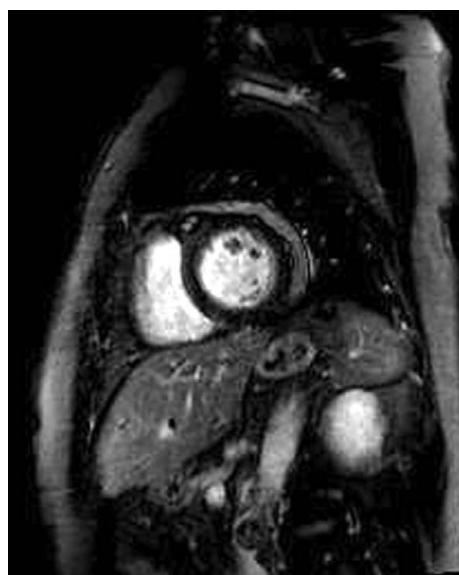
Cardiac magnetic resonance imaging of the patient shows no late gadolinium enhancement.
